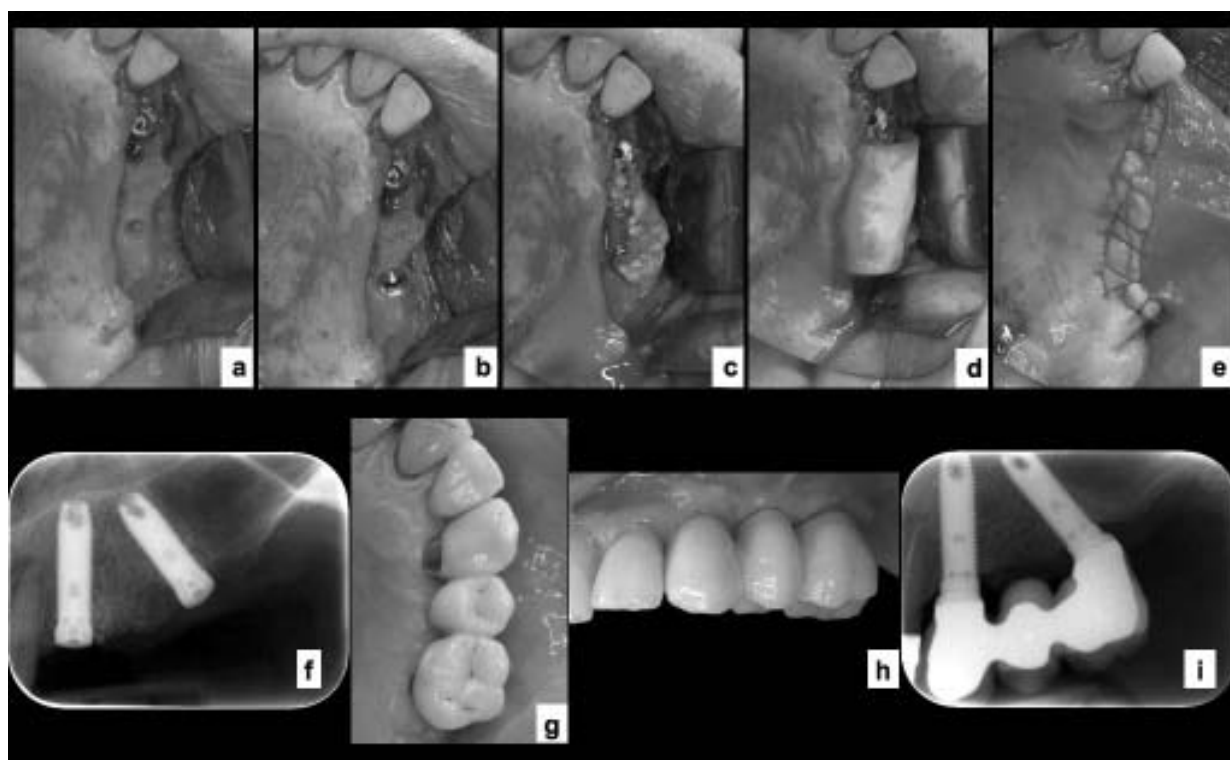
Continuation of Fig. 1: a) the distal implant tunnel is prepared; b) the distal implant is placed with an inclination as to allow the use of a standard titanium abutment, with a maximum inclination of 25°; c) the bone graft is applied when needed; d) the graft is protected with a resorbable membrane; e) the flap is sutured; f) the post-operative X-ray; g, h) clinical condition at one year follow-up; i) radiographic condition at one year follow-up.
